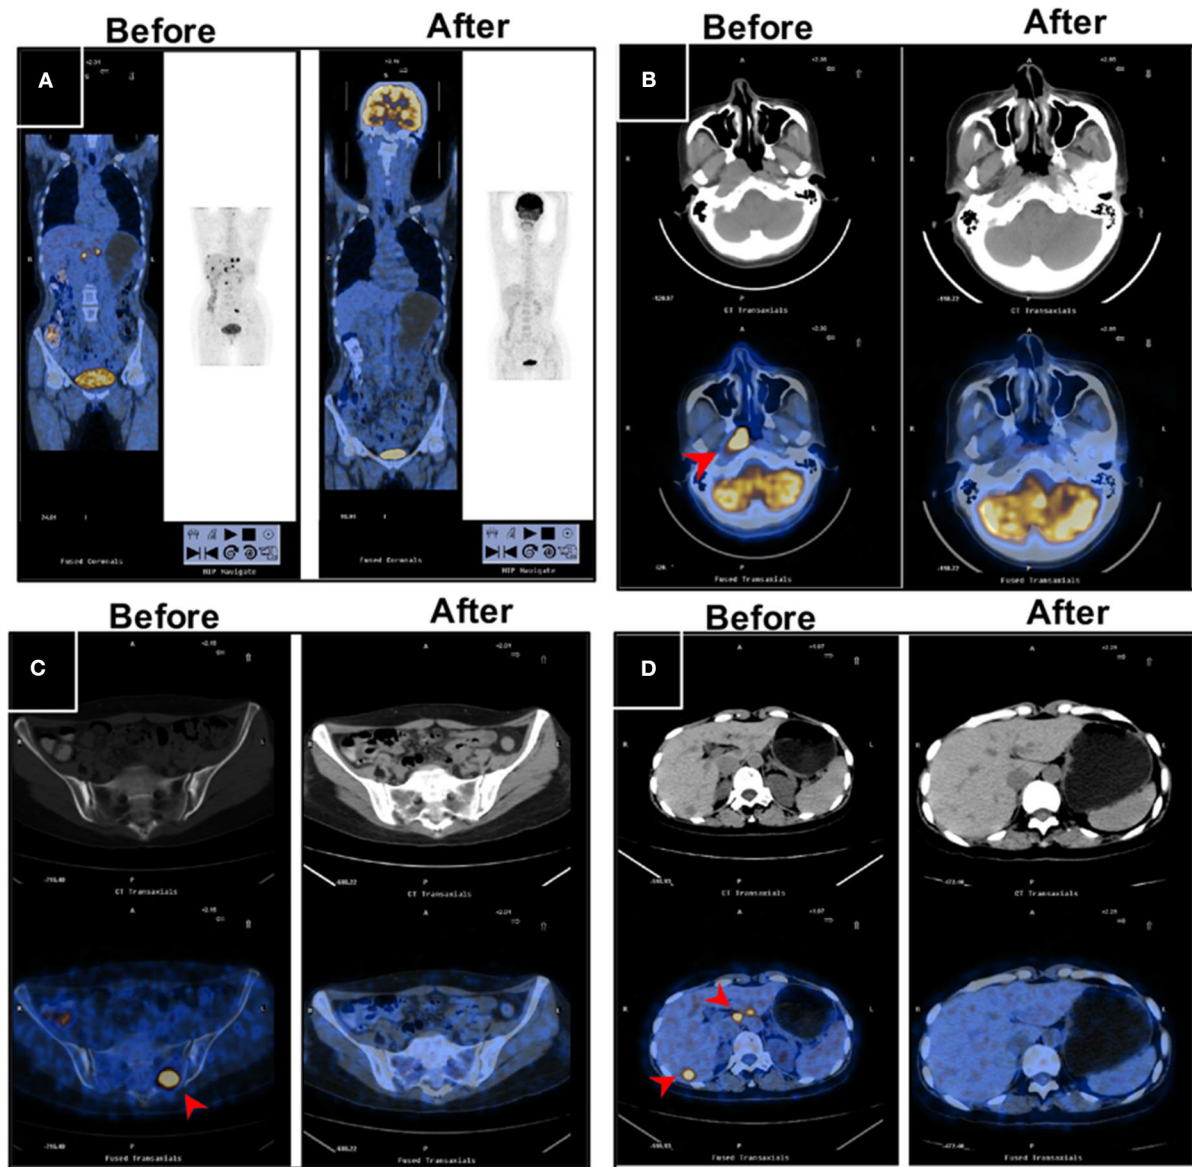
PET/CT images for a long-term disease-free patient before and after the novel regimen. The female patient, 48 years of age, with an initial diagnosis of nasopharyngeal carcinoma with bone and liver metastases, EBV+, survived without disease for more than 120 months. (A) The systemic lesions, (B) the primary nasopharyngeal tumors, (C) the bone metastases, and (D) the liver metastases disappeared or decreased after treatment compared with before treatment.
